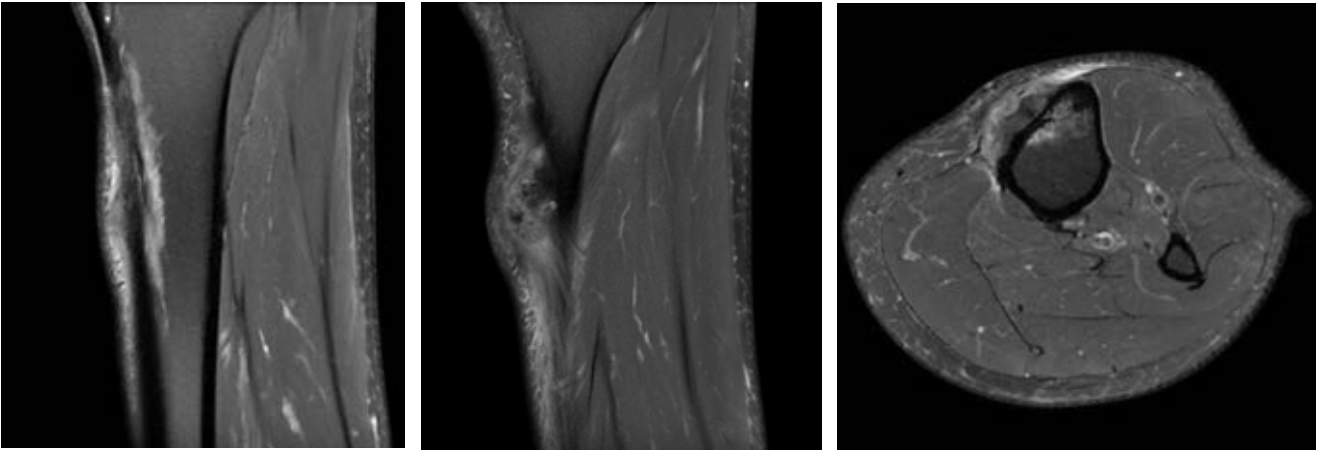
MR image of the tumor showing growth from the anterior periosteum and internal calcification. Soft tissue invasion can be seen.
